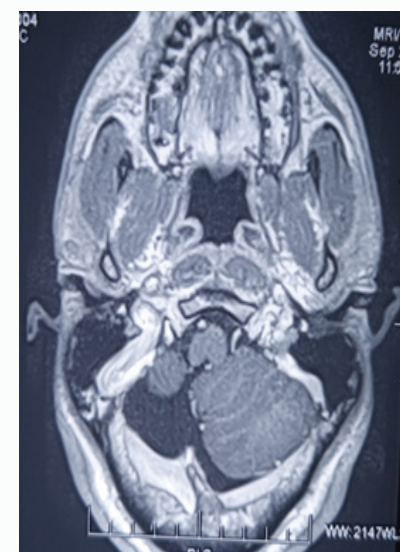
T2W brain MRI, axial slice, showing a hypoplastic right cerebellar hemisphere, increased cisterna magna and an asymmetric posterior fossa.
